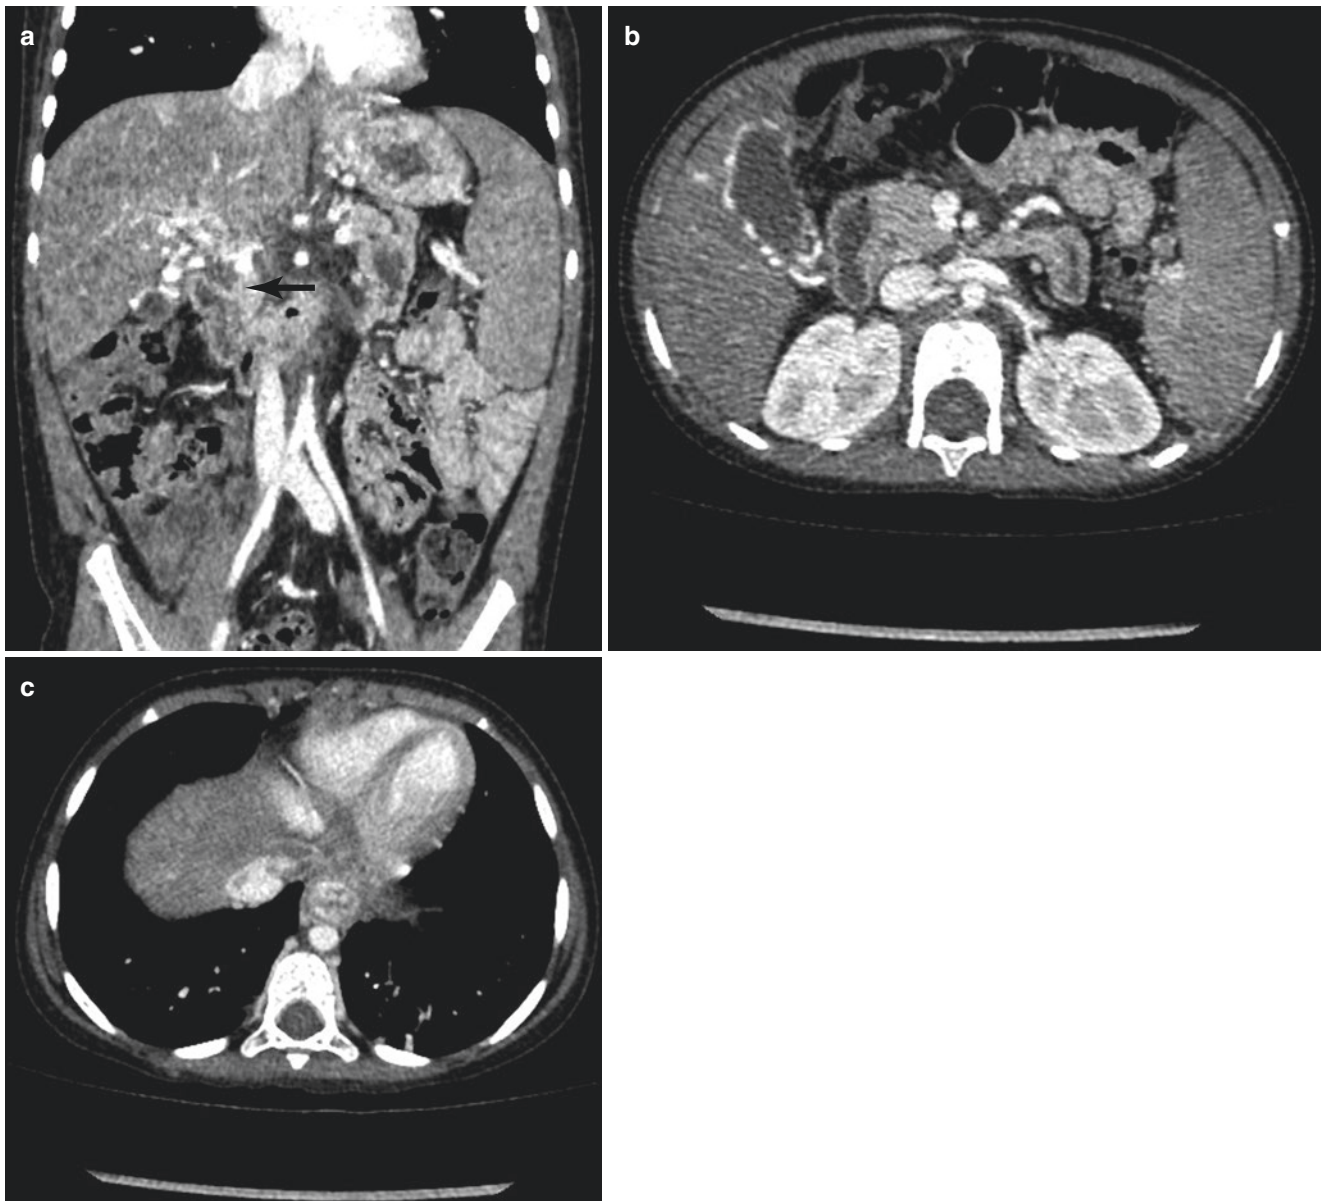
(a–c) Post intravenous contrast enhanced MRI axial and coronal sections of the abdomen reveal cavernous transformation of portal vein at porta with extensive varices around the stomach, gall bladder, lower oesophagus with splenomegaly
